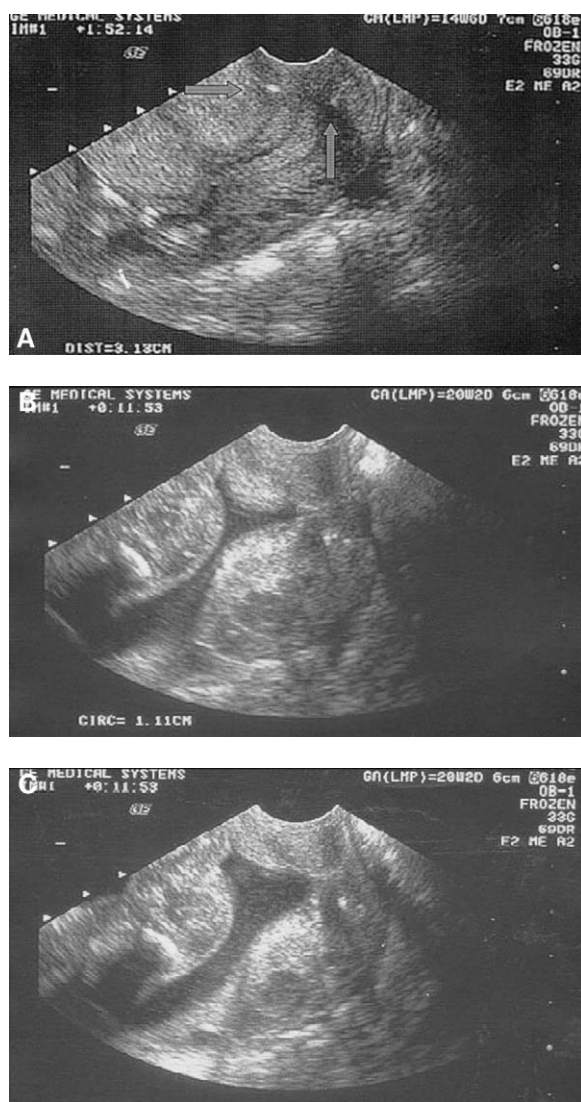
This patient had a classic history of cervical incompetence in her first pregnancy. In her second pregnancy, a cerclage was placed at 14 weeks' gestation. (A) The cerclage is visible (arrows) at 15 weeks' gestation and cervix measures 31.3 mm. She had weekly ultrasounds following cerclage placement. (B) At 20 weeks', the cervix had shortened to 11.1 mm. (C) Dynamic changes were noted with funneling.
